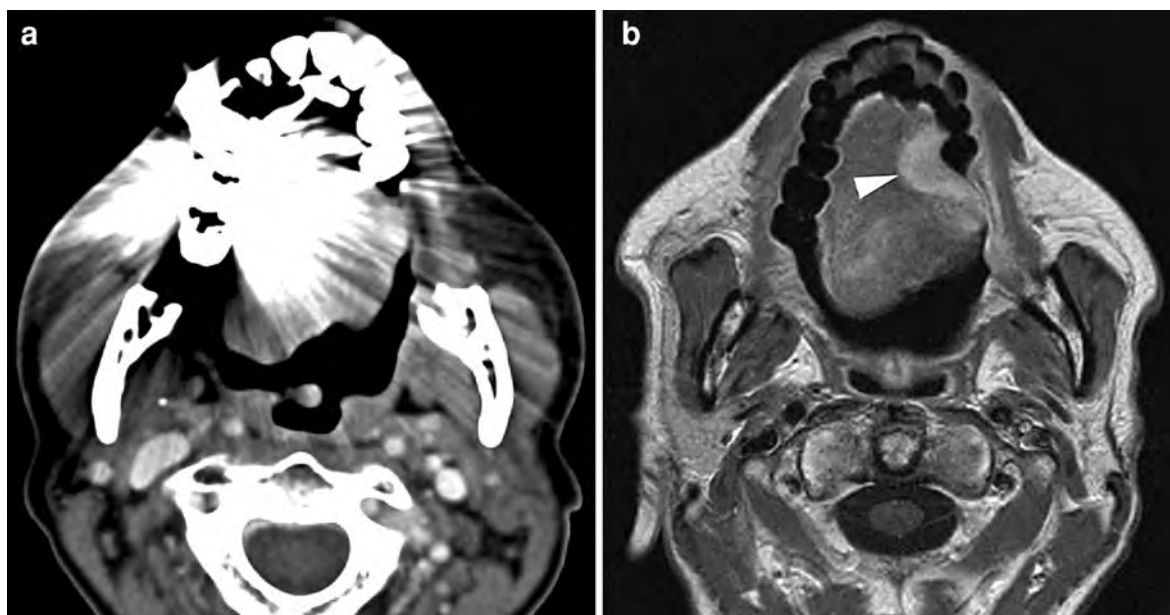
Patient suffering left-sided oral tongue cancer. a Axial contrast-enhanced CT-image. As the image quality is severely hampered by artifacts arising from dental fillings, the primary tumor is not visible. A complementary MR-study was advised.
